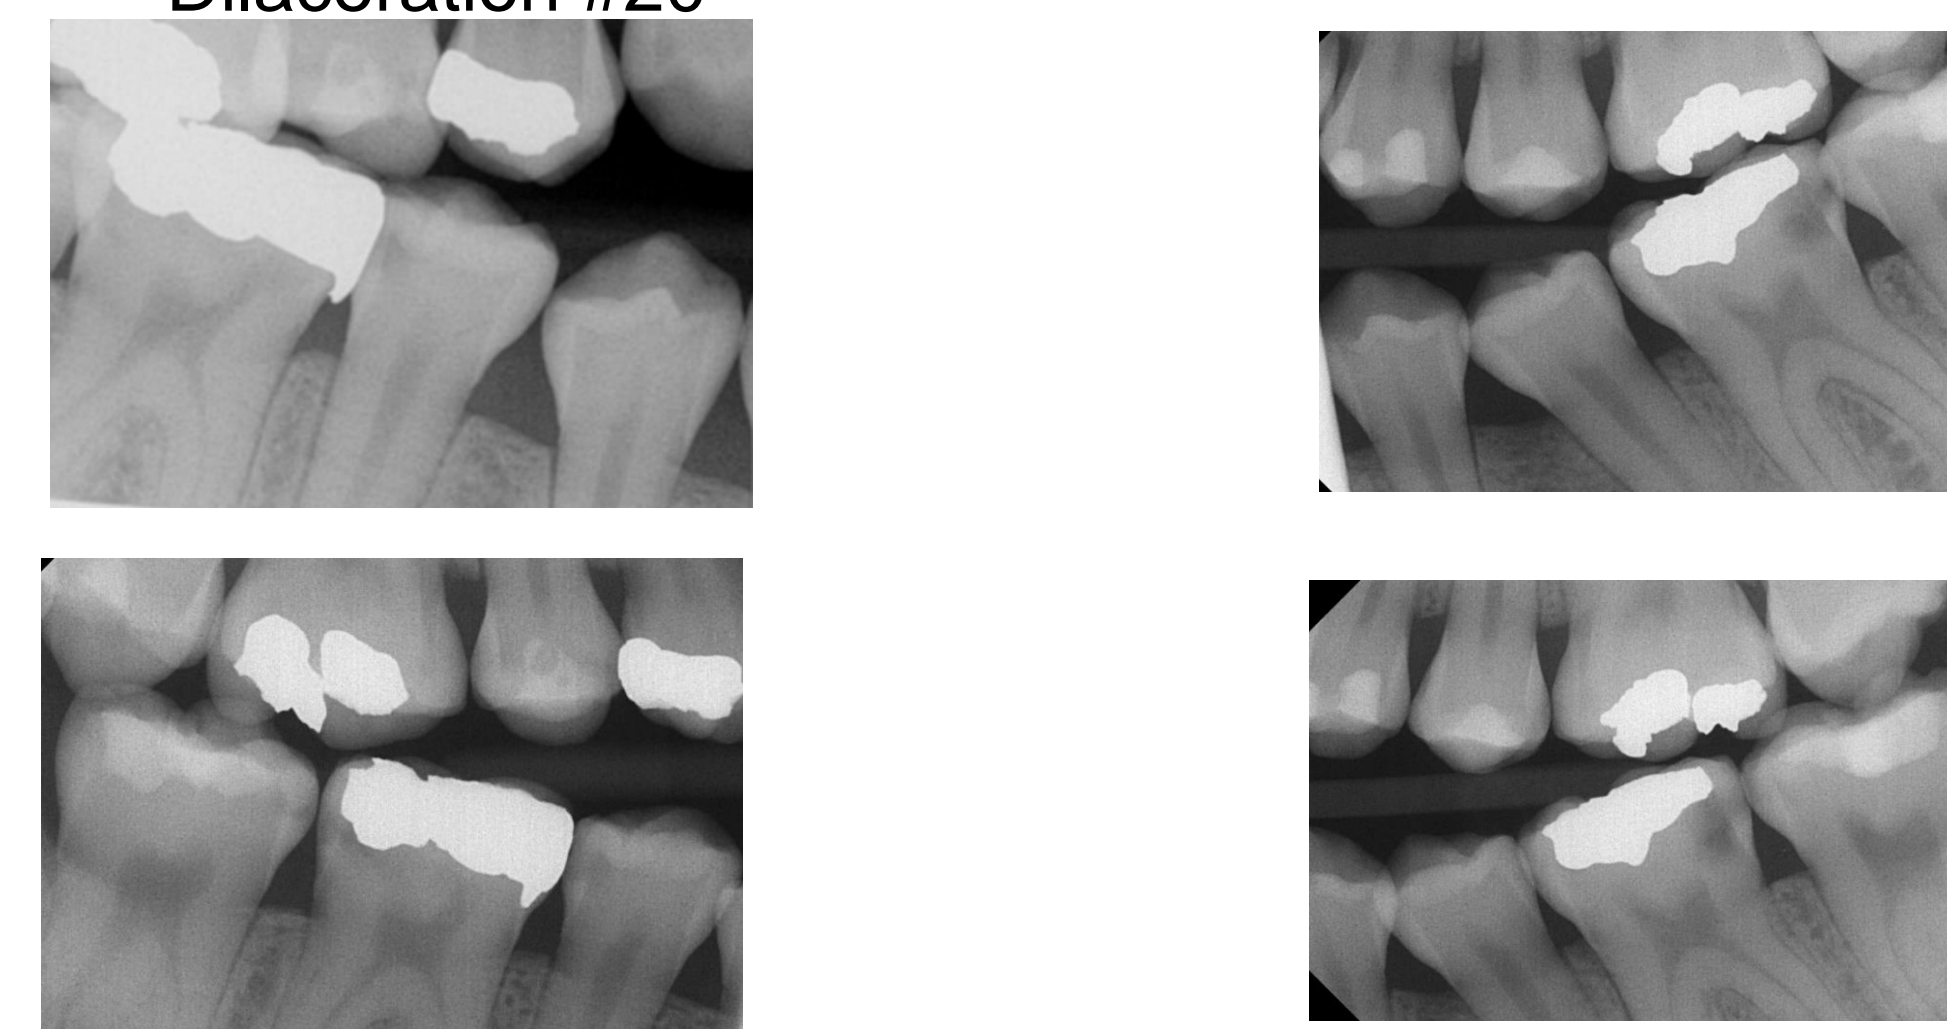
Bitewing Radiographs. Restoration on tooth #2(O), #3(O), #4(O), #5(DO), #11(O), #14(OL), #18(O), #19(O) and #30 MOB
